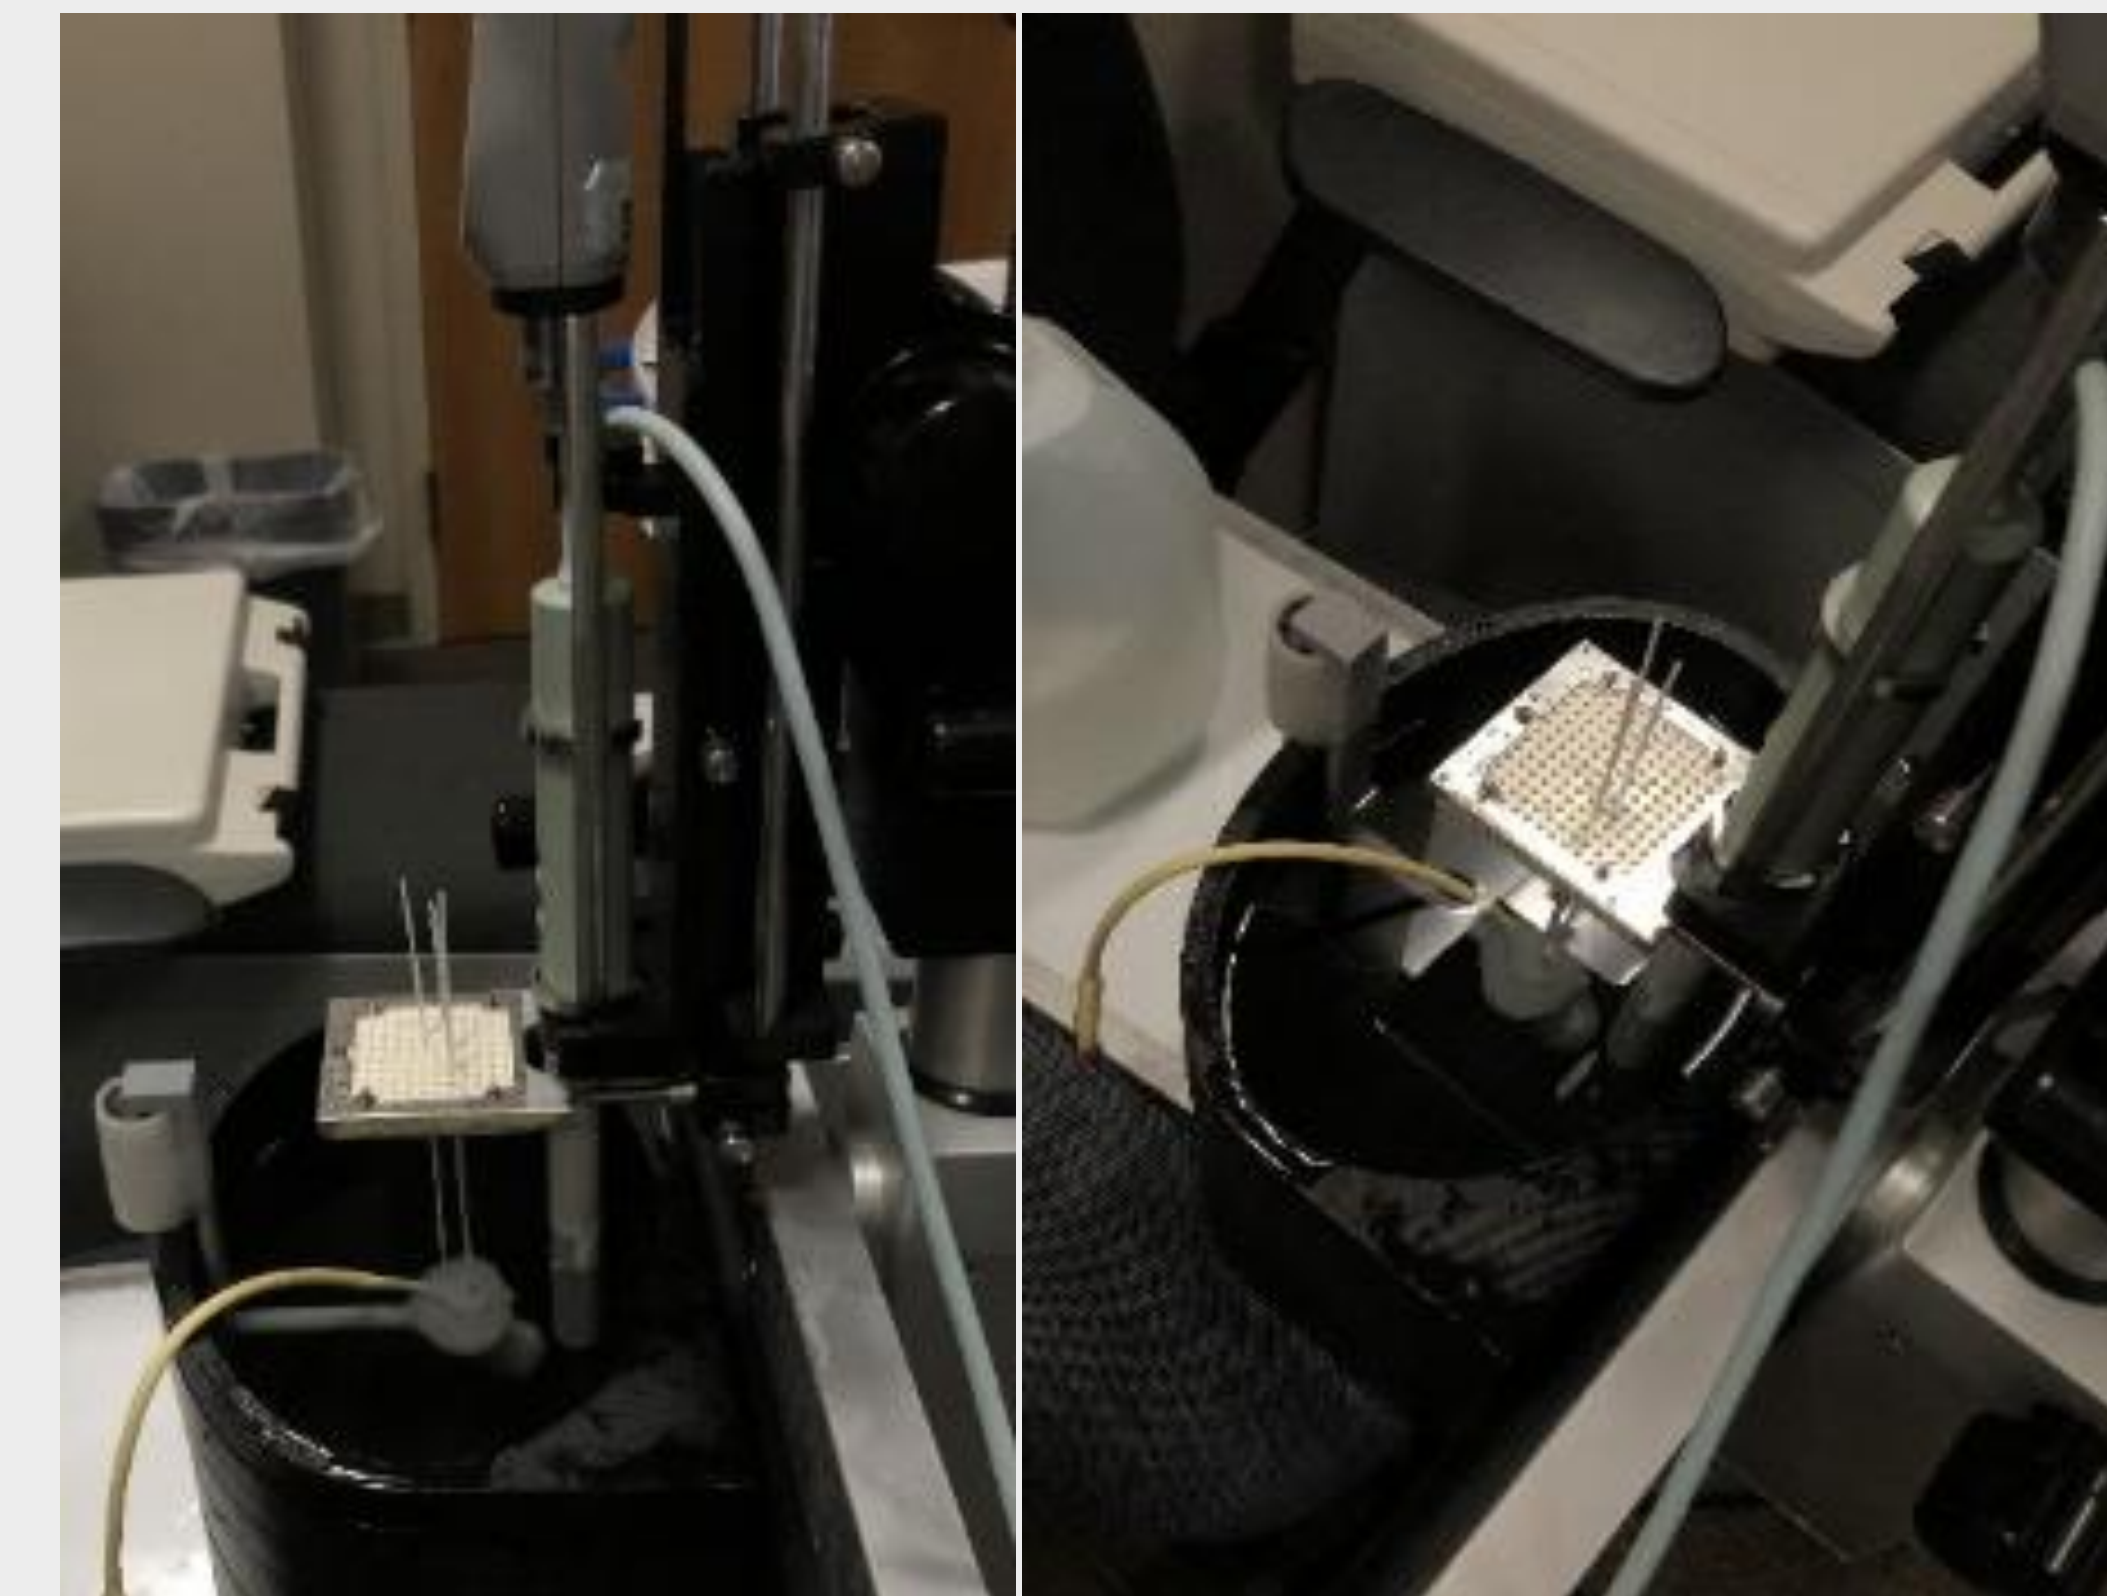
Imaging setup with ultrasound probe, stepper, and template; needles placed at b3.0, D3.0, E4.0.
